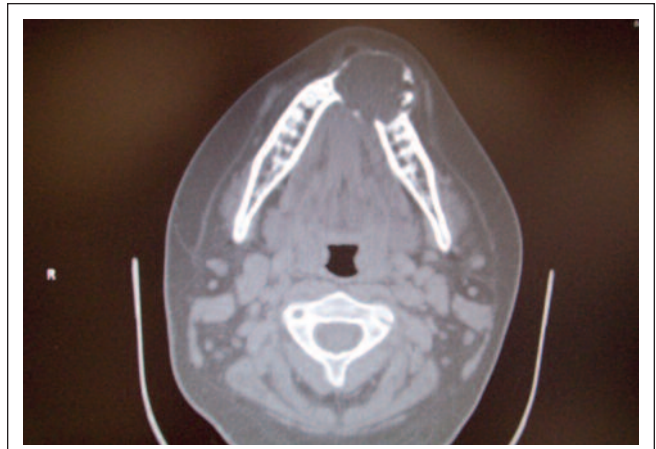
Axial Contrast-Enhanced Computed Tomography (CECT) of the mandibular region reveals an expansile, low density lesion with internal foci that is causing thinning of the buccal and lingual cortices. Notice the teeth displacement and the extension anterior to the platysma muscle and posterior to the floor of the mouth.
